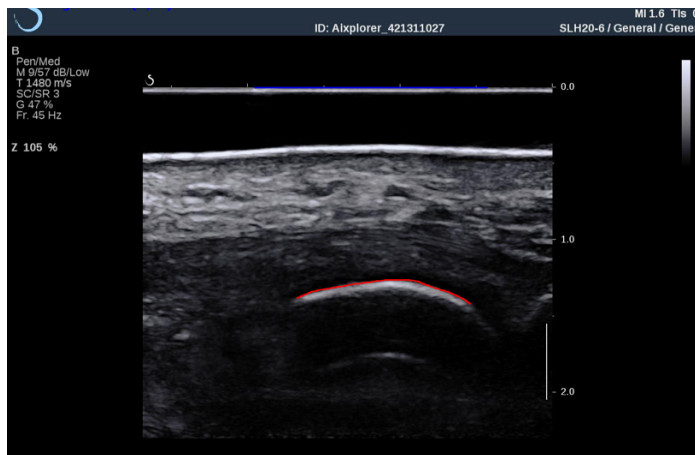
Labeled ultrasound image of the second metatarsal head (red) and probe (blue) labeled.
